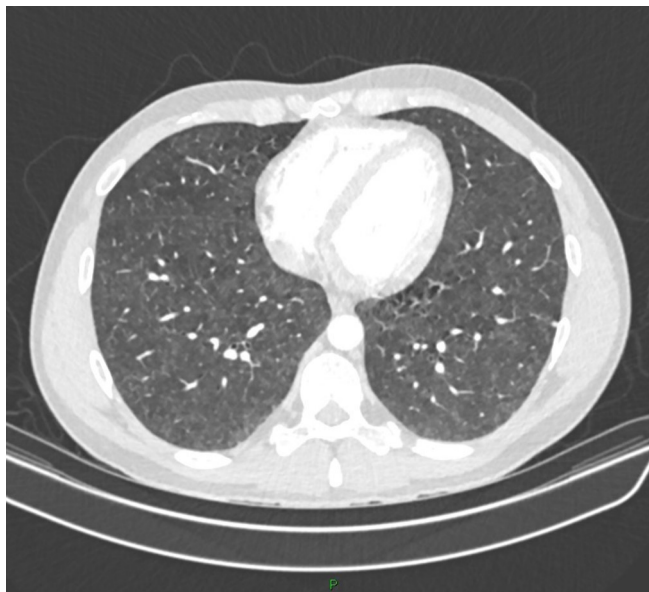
Initial CT pulmonary angiogram demonstrating ground-glass nodularity.
